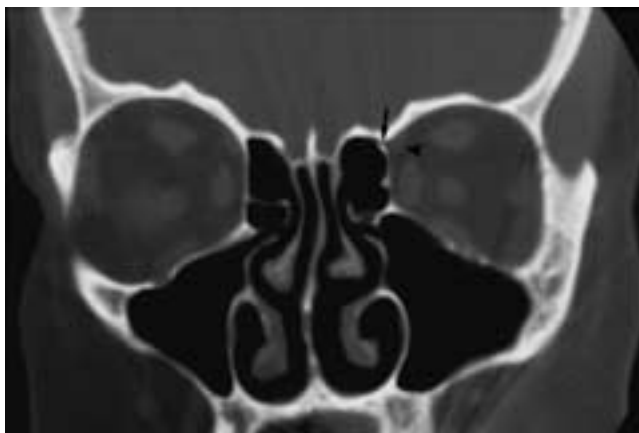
Anterior ethmoidal artery canal. Coronal CT scan. Note the narrow bony canal (*arrow*) on the left at the superior aspect of the medial orbital wall, just medial to the superior oblique muscle (*arrowhead*). Visualization of the canal is variable and was not seen on the contralateral side in this patient.
